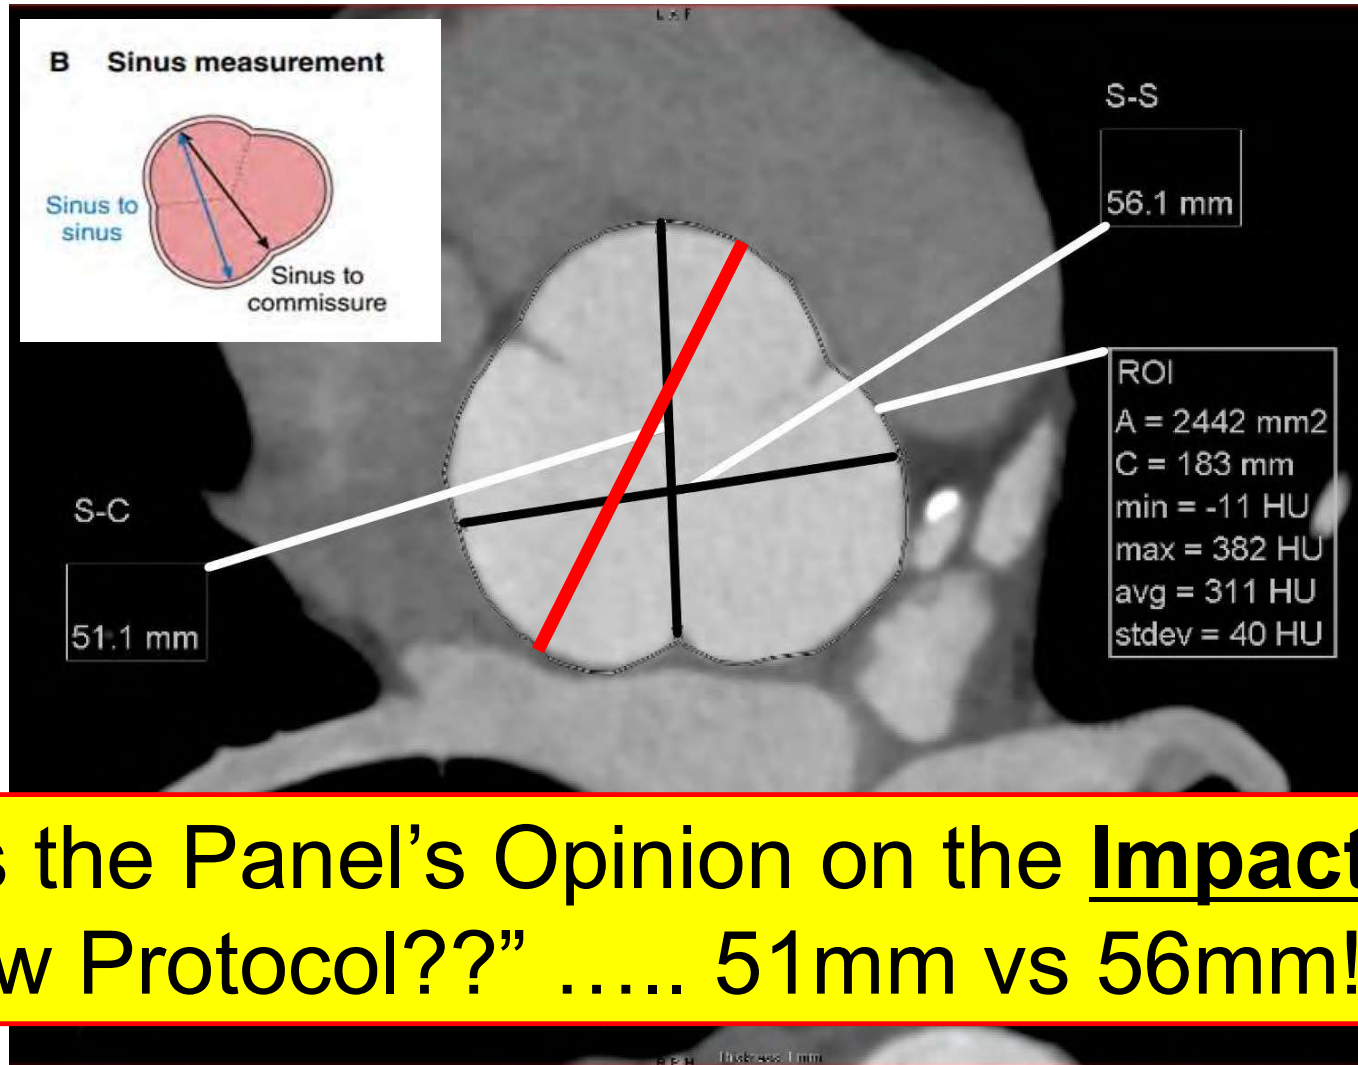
Reformatted CT Image Orthogonal to the Aortic Root at the Level of the Sinuses of Valsalva.
